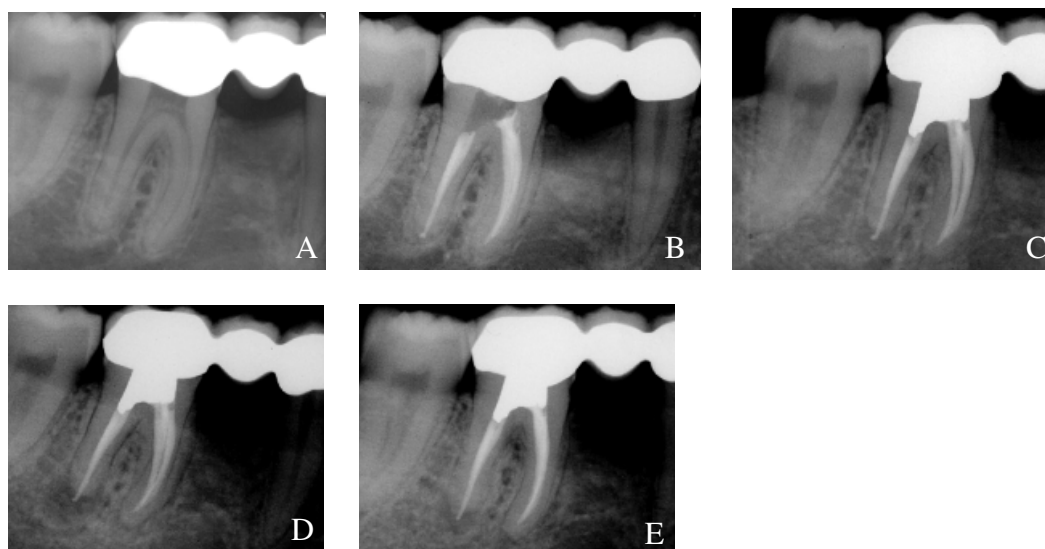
Pulpectomy of tooth #46 because of a symptomatic pulpitis after completion of bridge reconstruction. (A) Preoperative radiograph. (B) Immediate postoperative control shows a small overfill of the distal root. (C) One-year control radiograph presents with a small osteolytic lesion at the distal root, while normal periapical bone structures remains on the mesial root. (D) The 2-year control radiograph shows a larger radiolucent area. Patient is comfortable and presents with no symptoms suggesting ongoing infection. In the 3-year control radiograph (E) the radiolucent zone associated with the distal root appears reduced. Tooth is comfortable.
